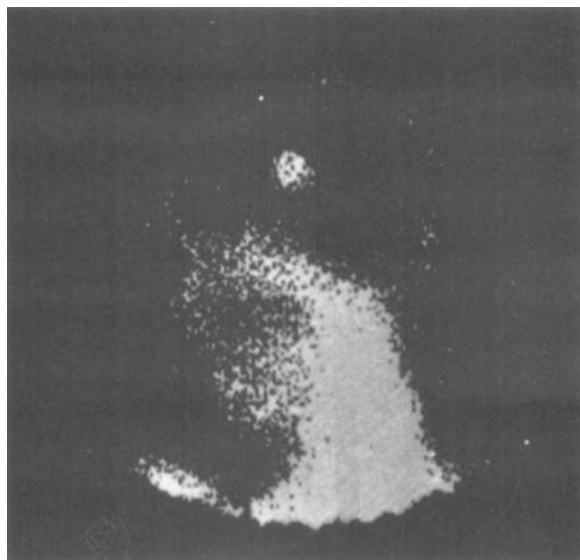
Brain metastasis of lung cancer visualized by radioimmunoscintigraphy (BW 431/31).
